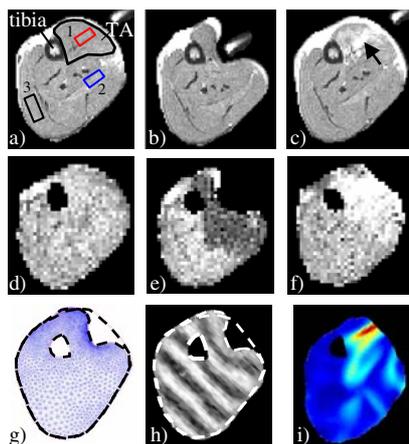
T2-weighted MR images a) before and b) during loading and c) 60 minutes after unloading. Perfusion index maps measured d) before and e) during loading and f) 5 minutes after unloading. g) Dedicated FE model and h) tagging MRI to determine i) local strain fields during loading
